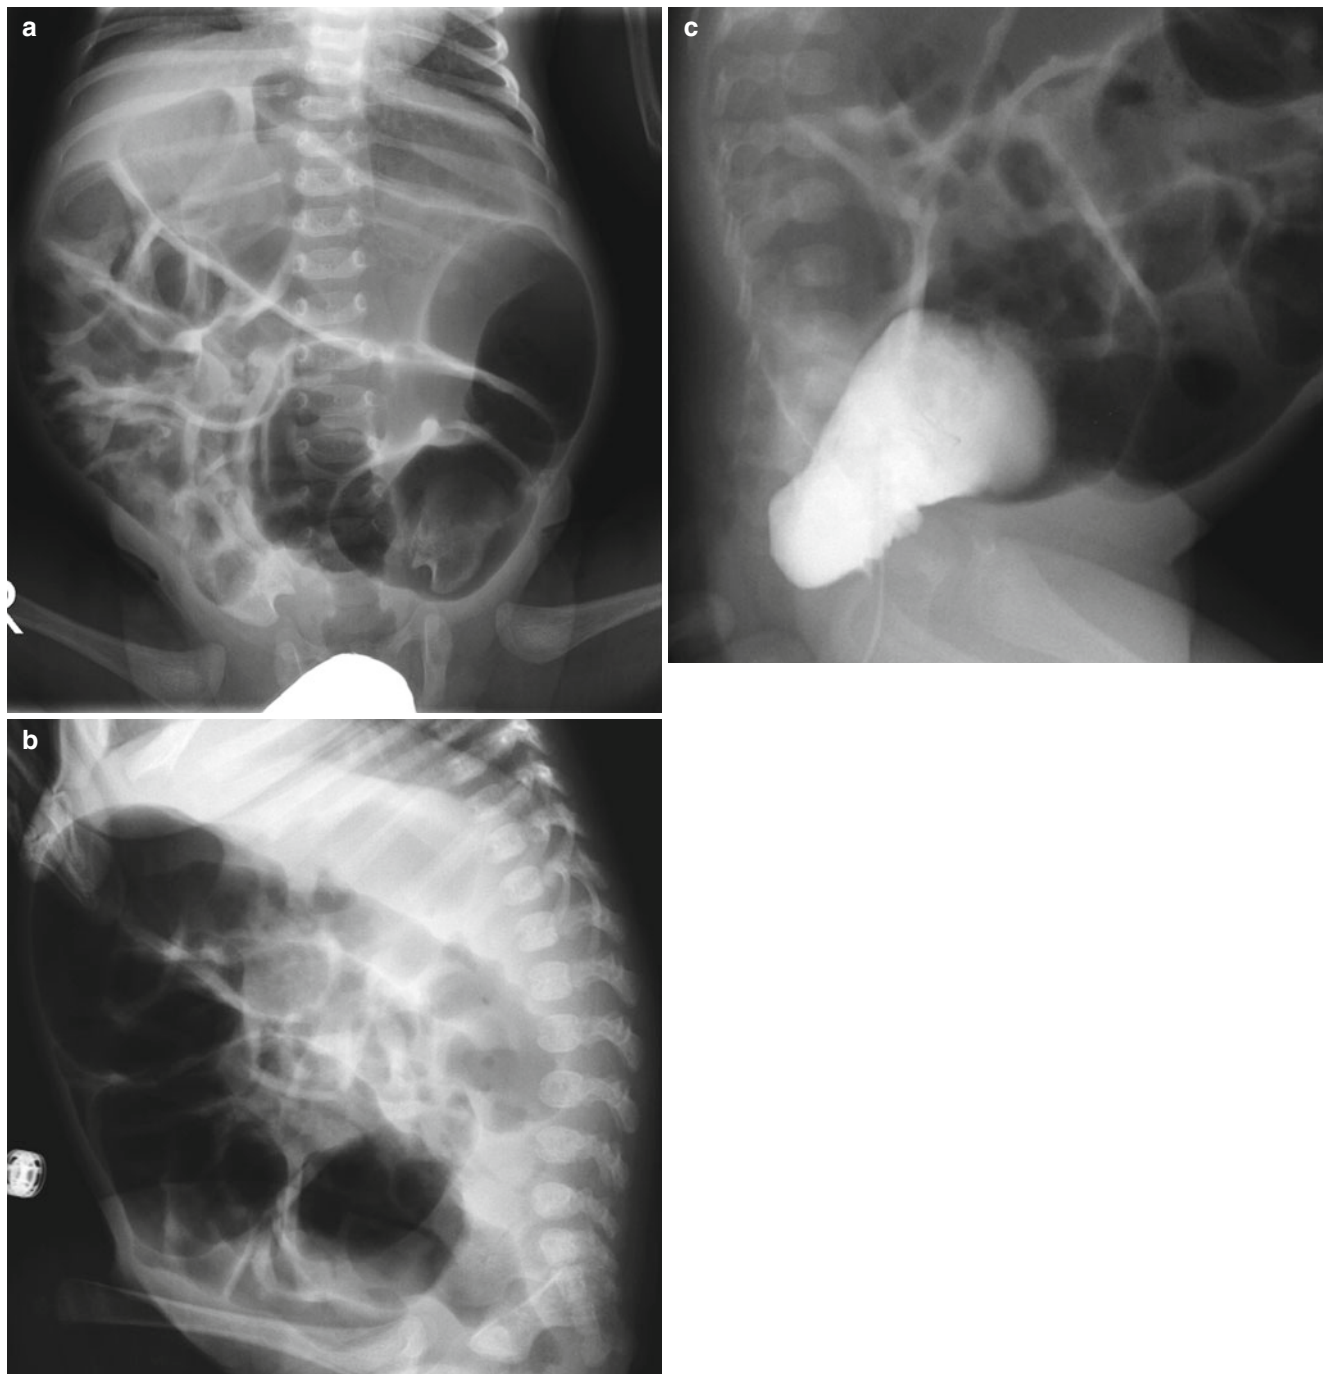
Hirschsprung disease in a 6-week-old infant presented with abdominal distension and vomiting. (a, b) Abdominal radiographs on supine and lateral view show marked gaseous distension of colon and small bowel with relatively decreased caliber of the air-filled
